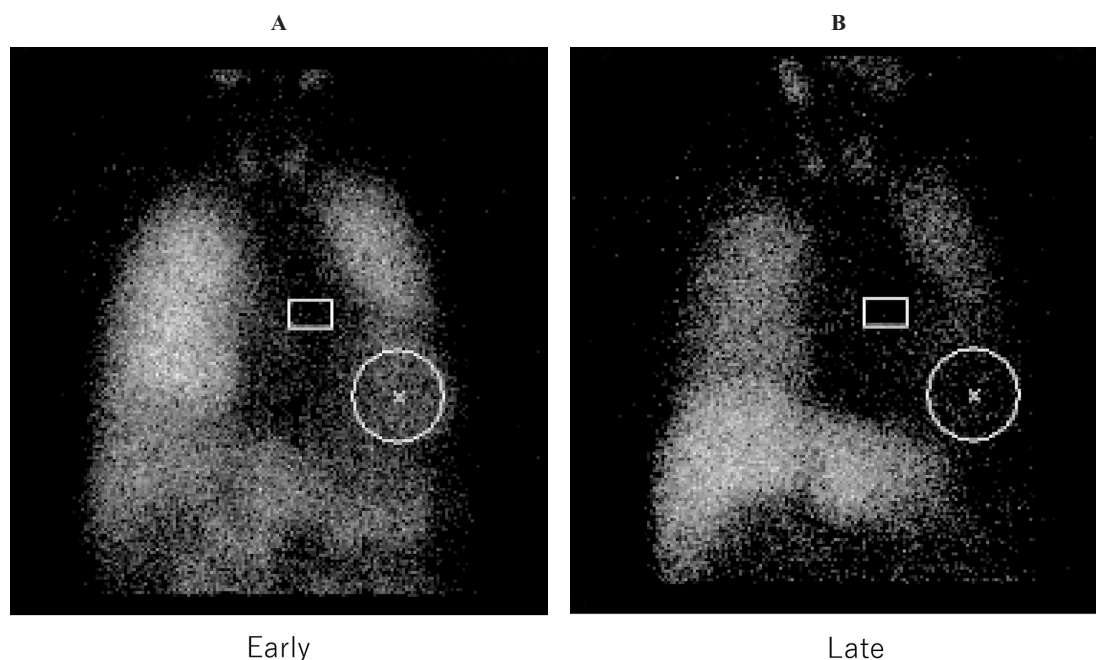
^{123}I -MIBG scintigraphy showed a decreased H/M ratio (early 1.83, late 1.35, the normal range is ≥ 2.2 in our hospital) and increased wash-out rate (69.7%, the normal range in our hospital is $\leq 30\%$). Early phase (A) and Late phase (B).
